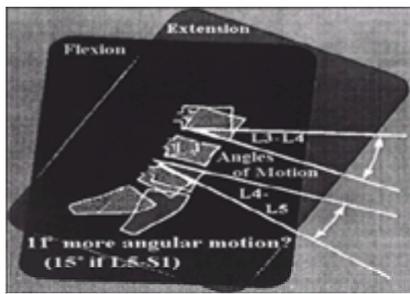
X-ray angular motion of instability. Superimposing a vertebra adjacent to the motion segment to be measured (here, L-4) from lateral films taken at the extremes of motion. The end-plates or posterior bodies can be used to measure the change in angular relationship from hyperflexion to hyperextension. Stress shielding occurs when there are more than 11 degrees of motion than the adjacent segments. (From Bigos SJ. *Housestaff handbook for back problems*. Seattle: SpineMate Publications, 1996.)
